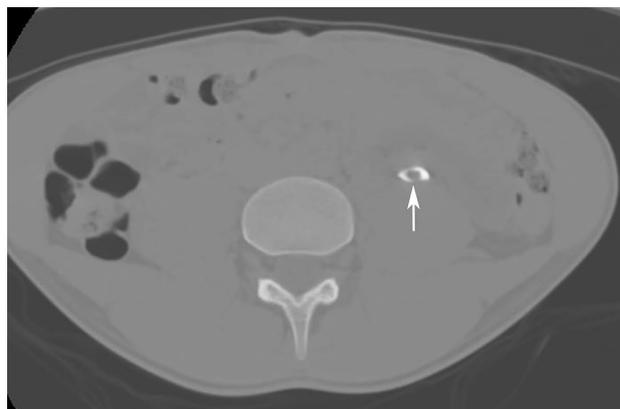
Fibroepithelial polyp. An axial excretory phase contrast-enhanced CT image shows a smooth filling defect in the left ureter (arrow). This was seen on multiple consecutive axial images, indicative of an elongated tubular configuration
